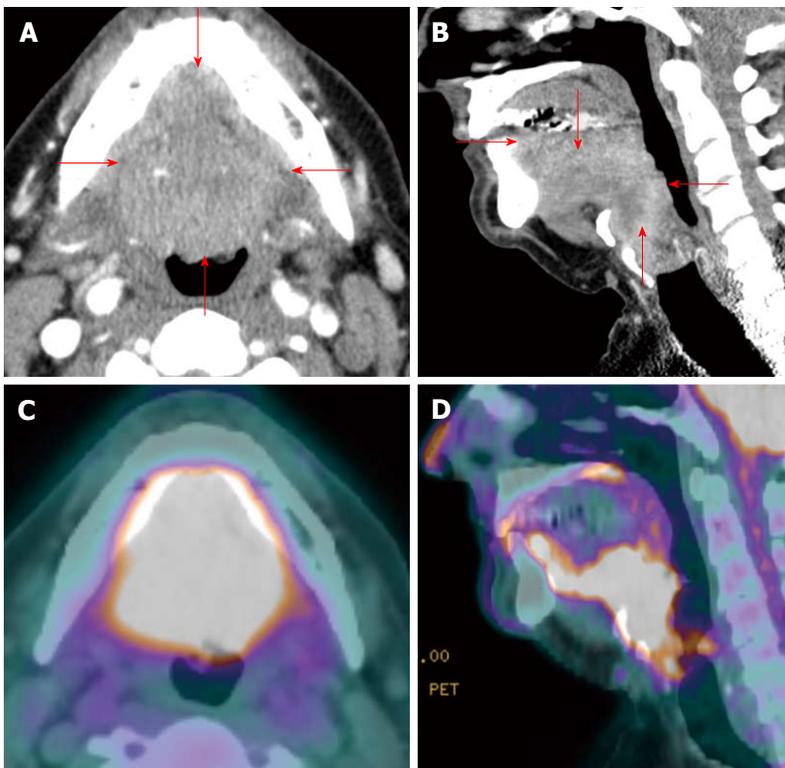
Positron emission tomography/computed tomography for delineation of oral cavity tumor extent. A T4a oral and base of tongue squamous cell carcinoma (red arrows) diffusely and symmetrically infiltrates the ventral aspect of the tongue, whose margins are difficult to appreciate on contrast enhanced computed tomography (CT) (A and B). On the other hand, positron emission tomography/CT (PET/CT) (C and D) clearly demarcates the tumor extent.
